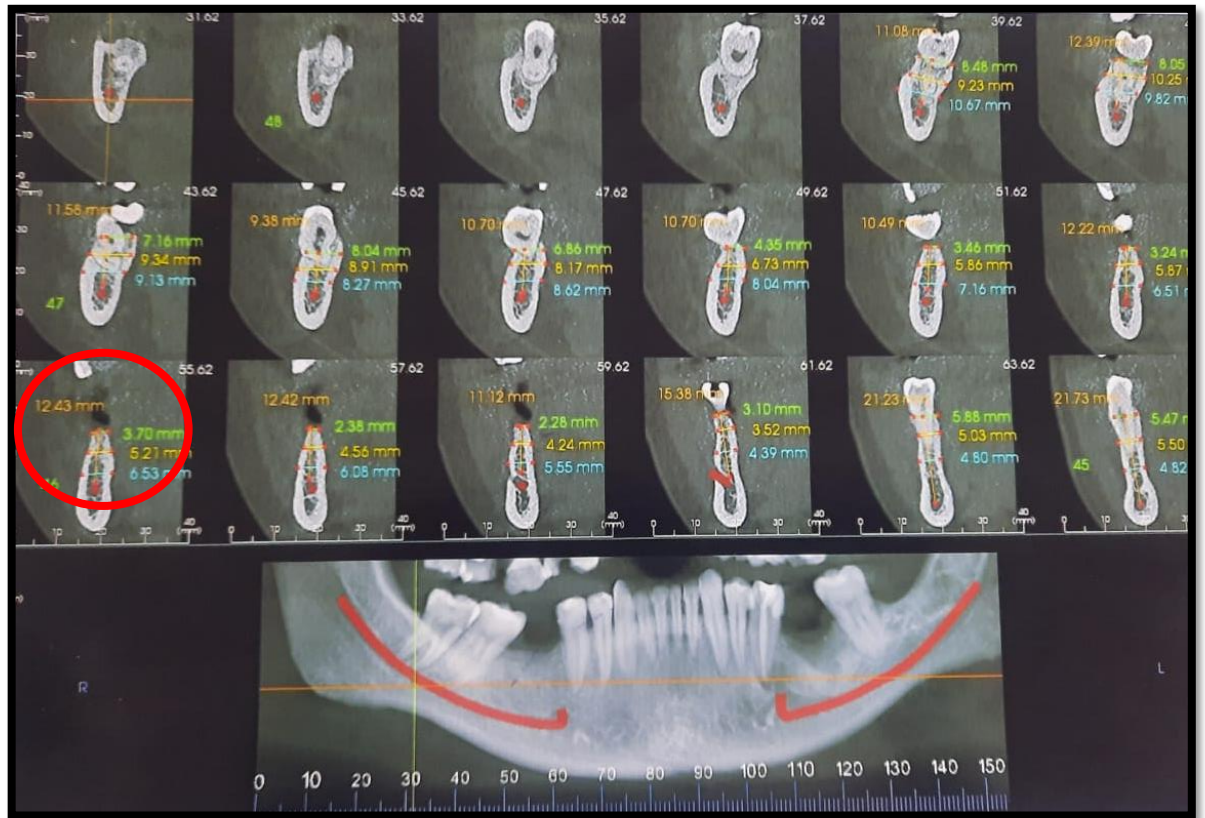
CBCT - coronal section
